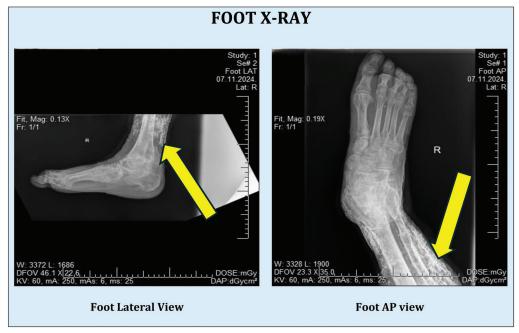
X-ray diagnostic of the right foot lateral (LAT) and anterior posterior views. Yellow arrow showing diffuse soft tissue calcifications embedded within muscles of the soft tissue
